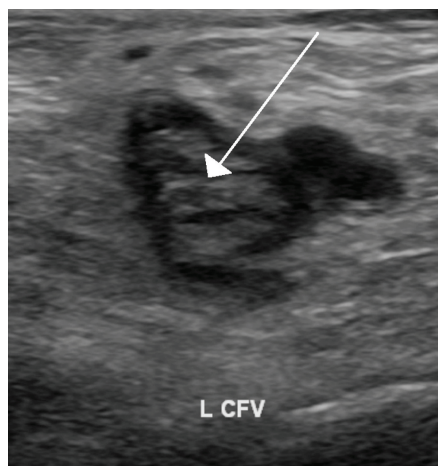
An ultrasound with a blood clot visible in the left common femoral vein.
